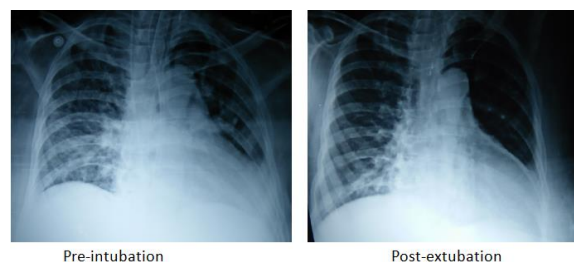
Chest radiograph (AP view)
